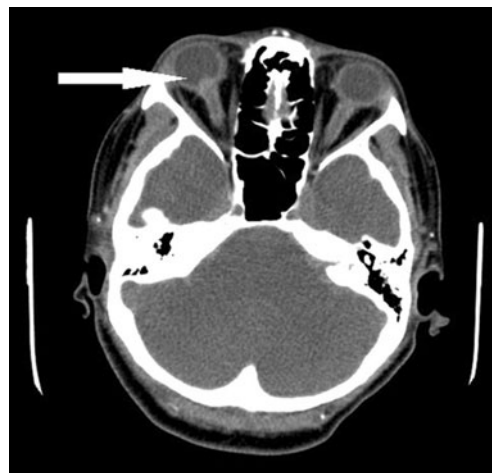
Axial noncontrast CT image demonstrates bilateral thickening and hyperdensity of the optic nerve sheaths compatible with dissecting subarachnoid hemorrhage. There is also accompanying focal thickening and hyperdensity partially visualized at the level of the right optic nerve head compatible with overlying Terson hemorrhage
